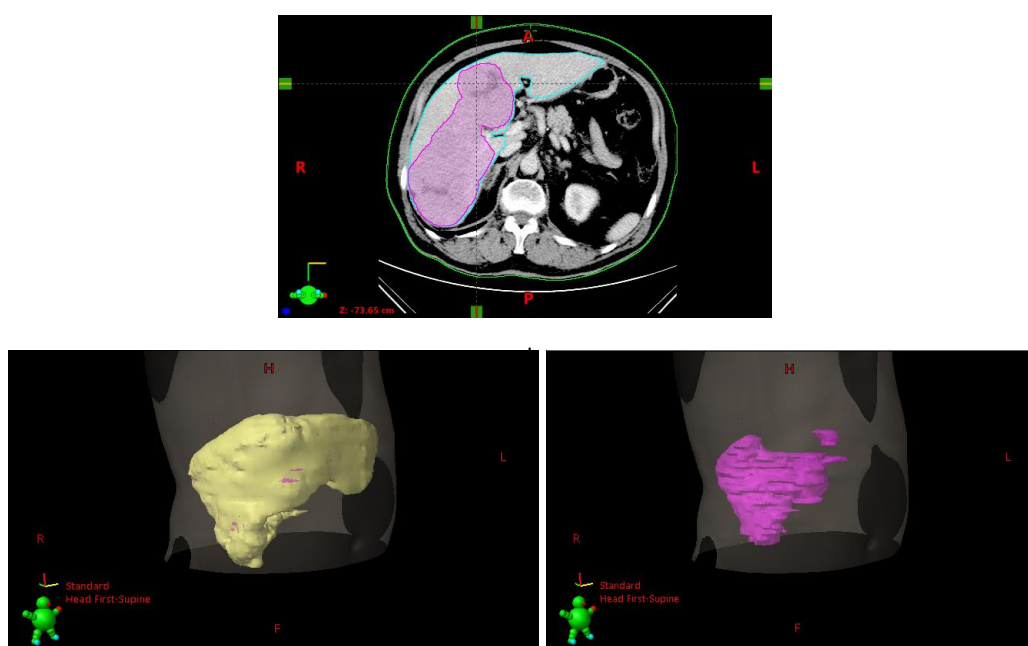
(I) Segmentation of liver and tumor on CT scan. (II) Representative liver from segmentation. (III) Representative tumor from segmentation.
